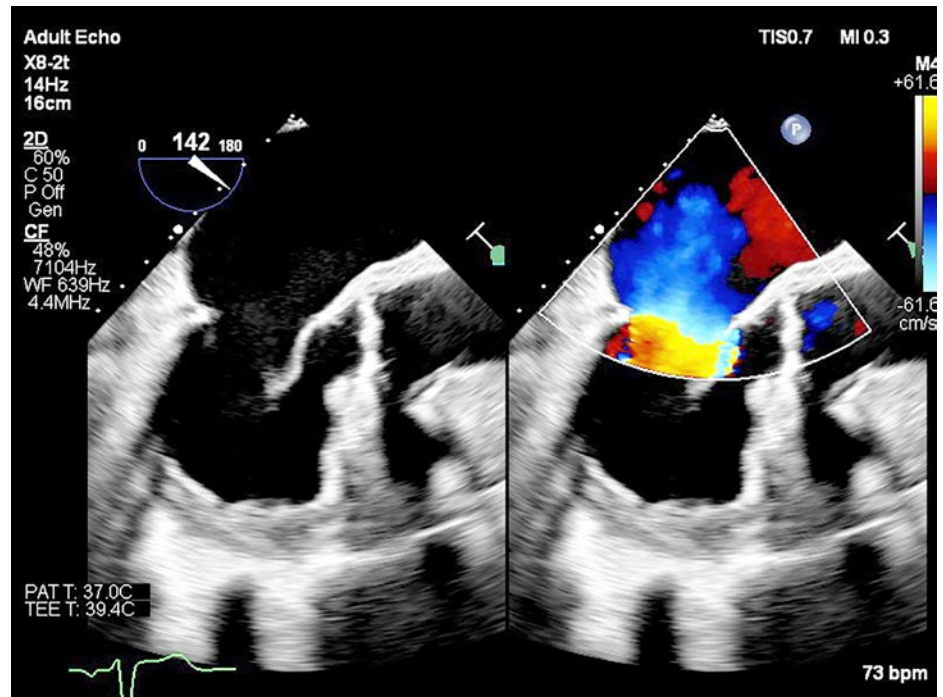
First echocardiographic evaluation of the mitral valve showing a septal bulge in the left ventricular outflow tract.
